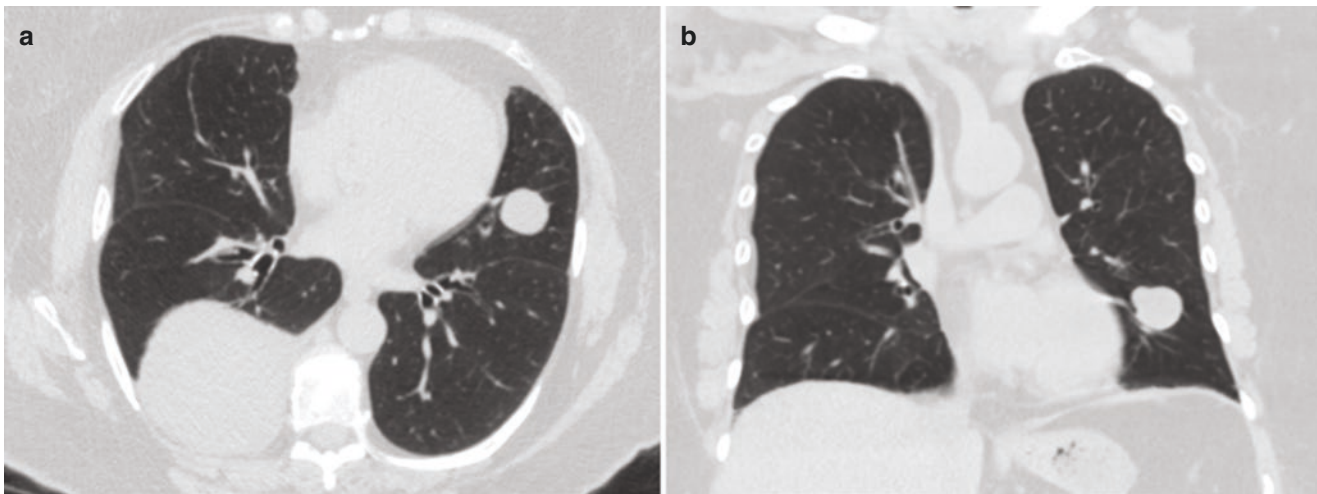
On CT imaging, BML usually demonstrates solid nodules of varying sizes. (a) Axial view; (b) coronal view
